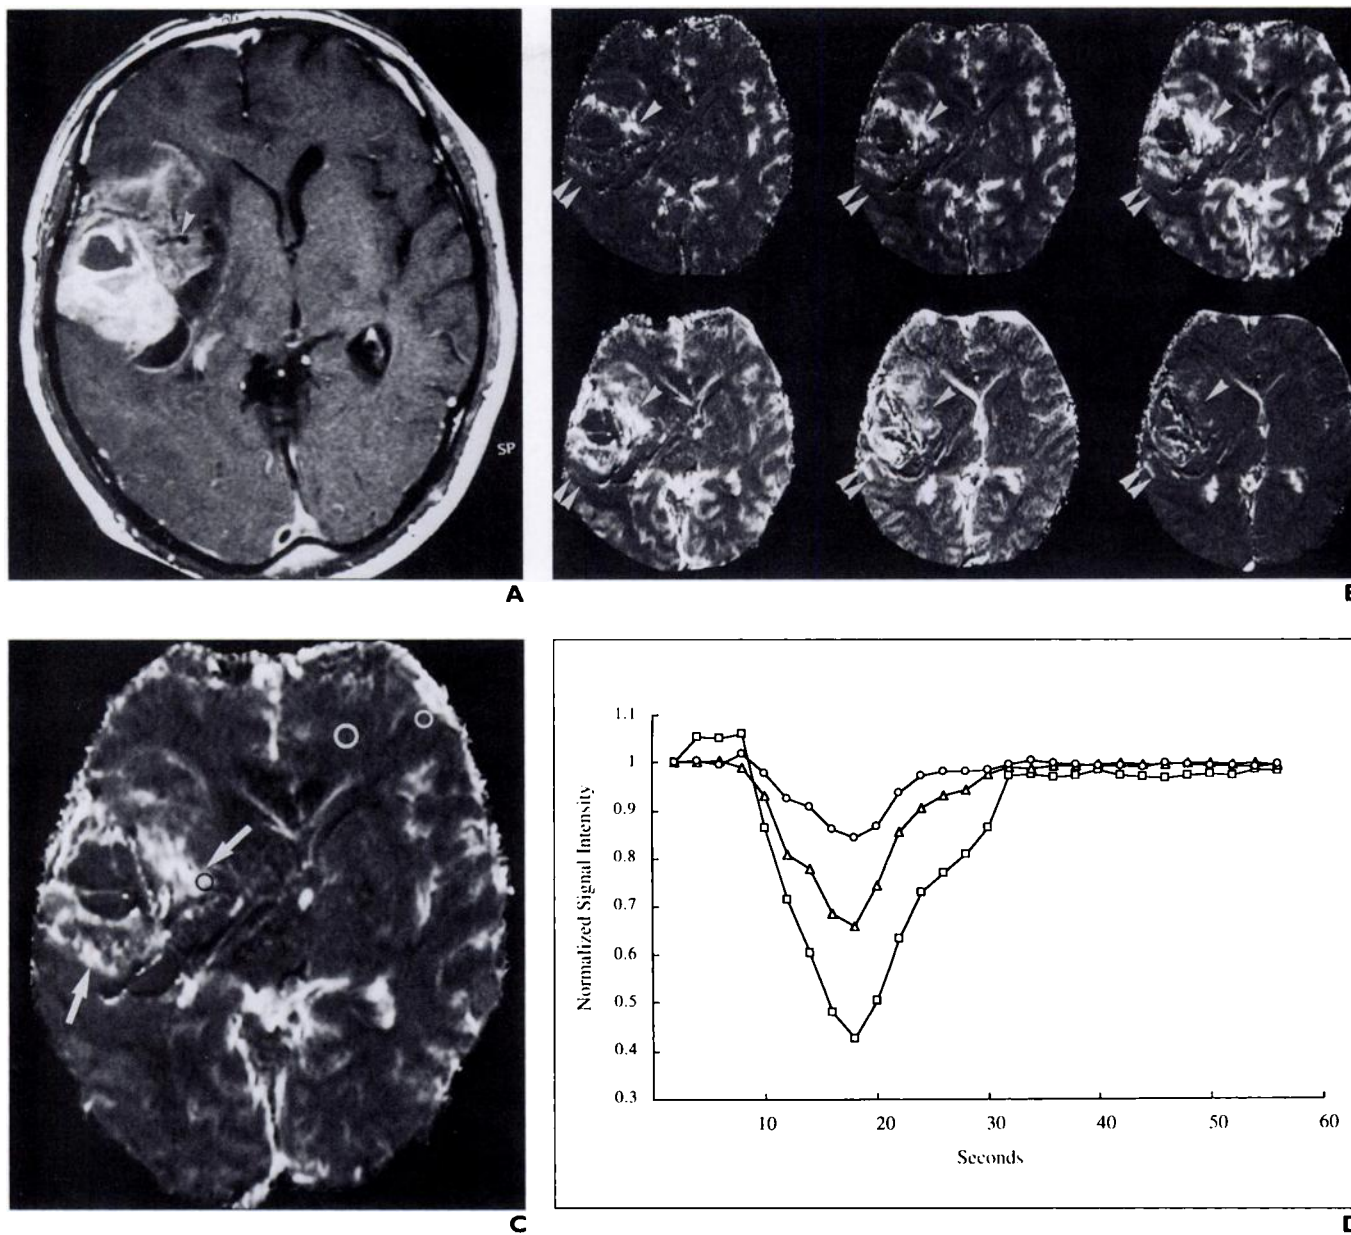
45-year-old man with anaplastic oligodendroglioma. A, Contrast-enhanced T1-weighted MR image shows nonhomogeneously enhanced tumor in right frontoparietal lobe. Note flow void effects suggesting that branch of right middle cerebral artery is displaced by mass effect (arrowhead).
